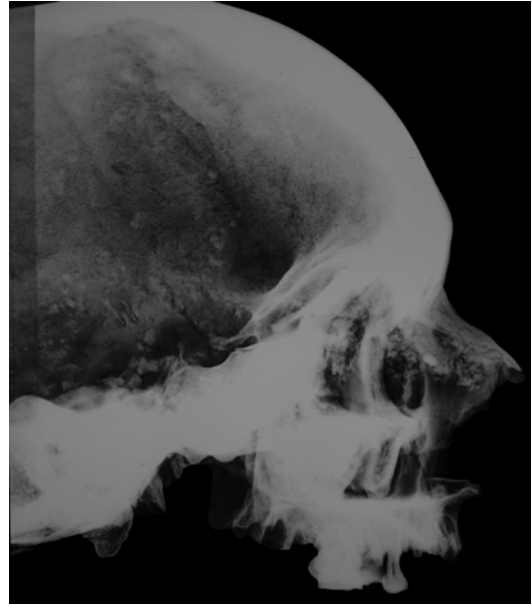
X-rays (lateral view) of the nose
